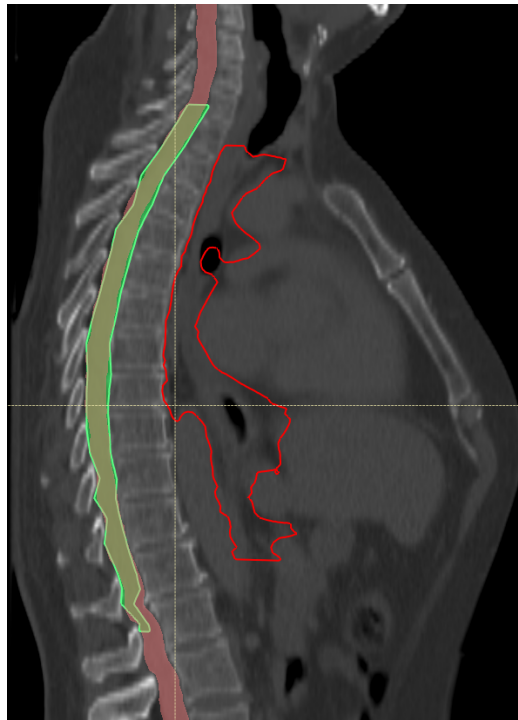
Patient CT scan showing the iCTV in red, the manually delineated spinal canal in green (shaded area) and the DL predicted spinal canal contour in pink (shaded area).
